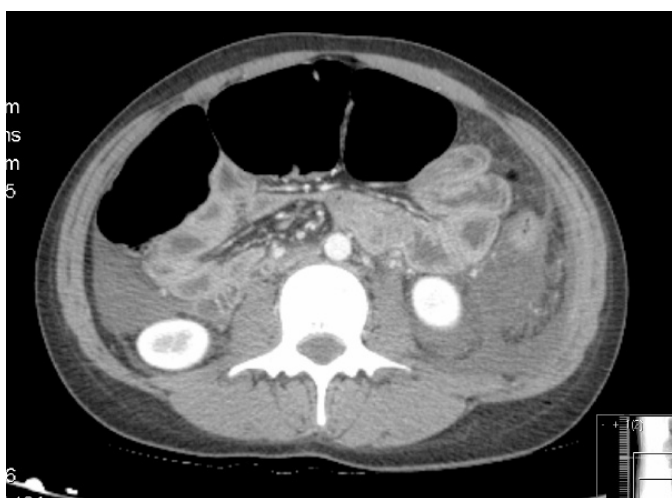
CT scan of abdomen and pelvis without contrast showed peritoneal, left retroperitoneal and pelvic ascites with likely ileus power 140 mA, 120 kV.
